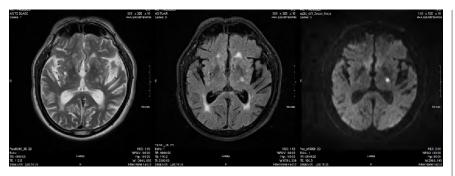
A brain MRI was consistent with acute lacunar infarct.
